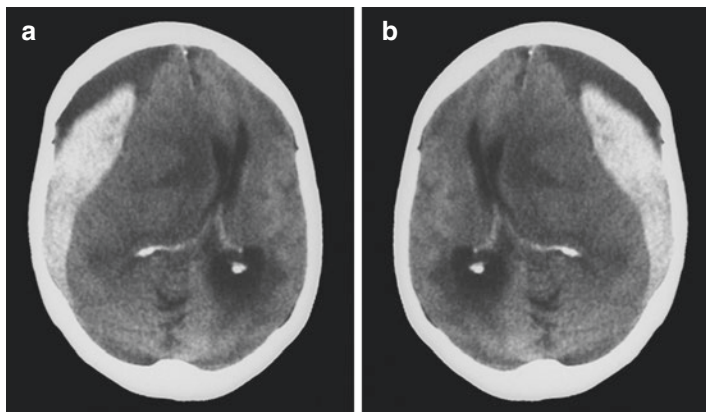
(a, b) Which side of the brain is this clot? It is so easy to inadvertently flip the CT films, or the convention adopted maybe different from what you are used to; so *ALWAYS CHECK THE LABELLING OF LEFT AND RIGHT!* See Figure 2.18
